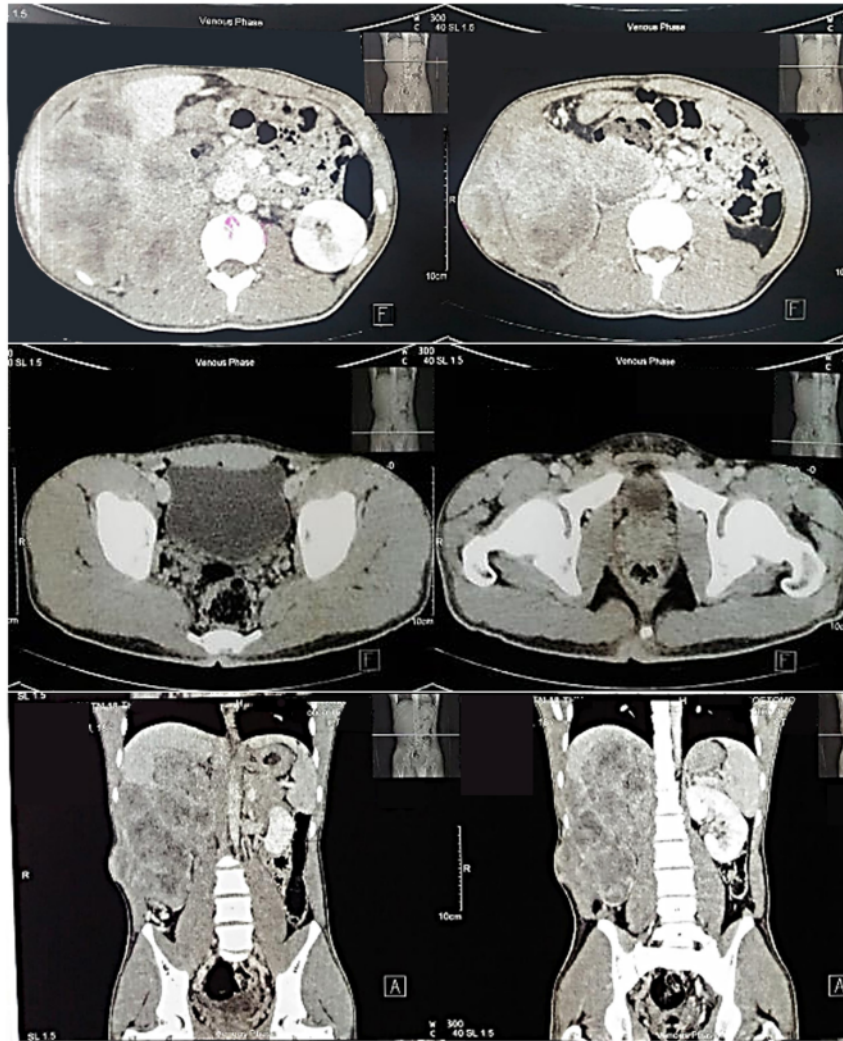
Abdominal computed tomography (R1) before chemotherapy.
